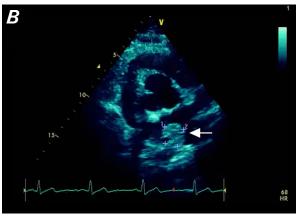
Transthoracic echocardiograms in A) parasternal long-axis view and B) parasternal short-axis view at the aortic valve level show a left atrial mass (arrows).
